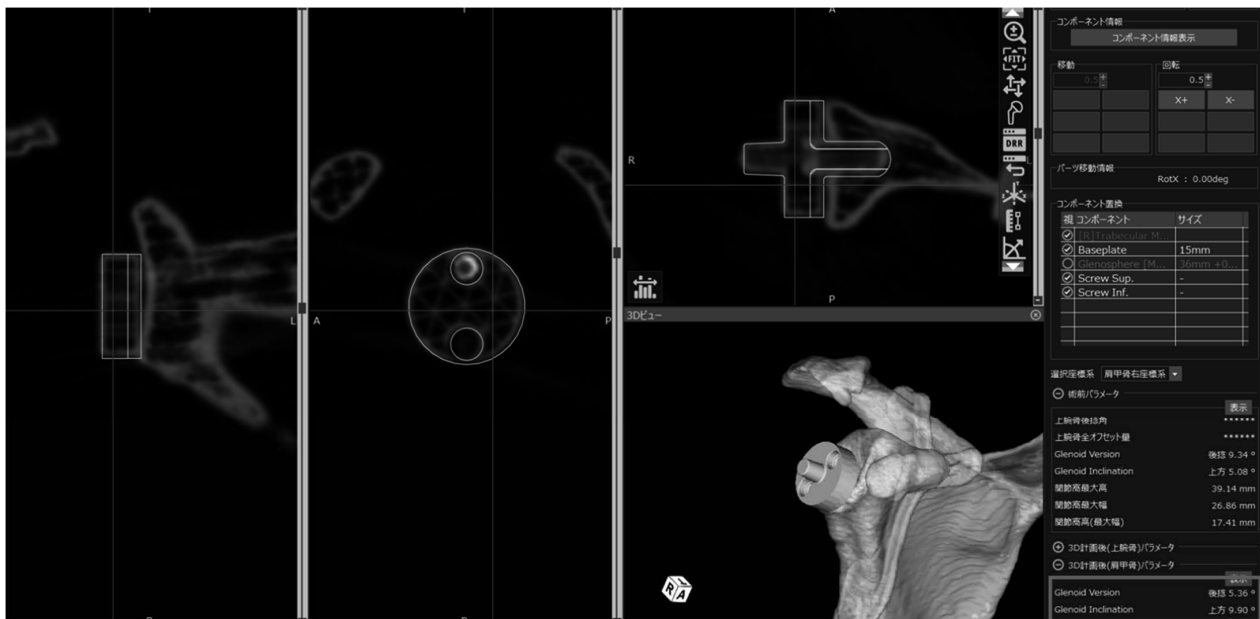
Positioning of the glenoid baseplate. The computed tomography data for each scan were transferred to three-dimensional template software (ZedShoulder, Lexi, Tokyo, Japan). The template was set with the planes. Inclination and version were measured correctly, as indicated by the red square.
